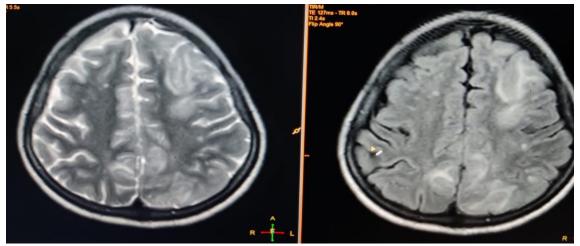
Axial T2-WI and FLAIR images showing T2/FLAIR hyperintensities noted in bilateral frontal and bilateral parietal lobes.
